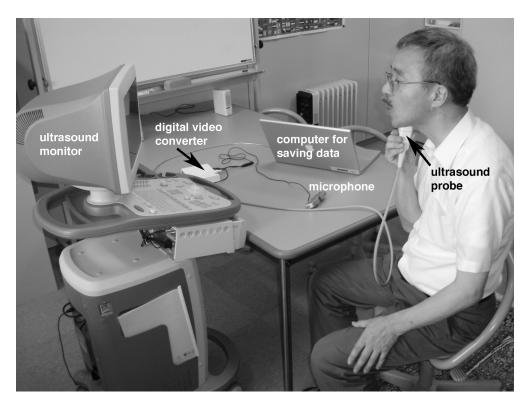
Ultrasound equipment setup for pronunciation session at the University of Aizu
